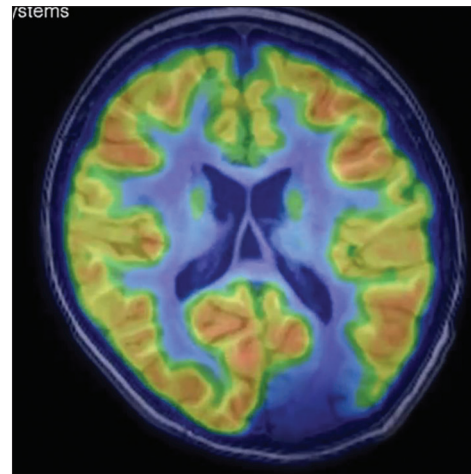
Latest 18-FDG PET MR fusion images with increased resolution showing a region of hypometabolism correlating with occipital lobe dysplasia on structural MRI in a drug-resistant epilepsy patient. Note the advanced resolution and clarity of images in comparison to Figure A (Courtesy:Nuclear medicine dept, AIIMS, New Delhi)
